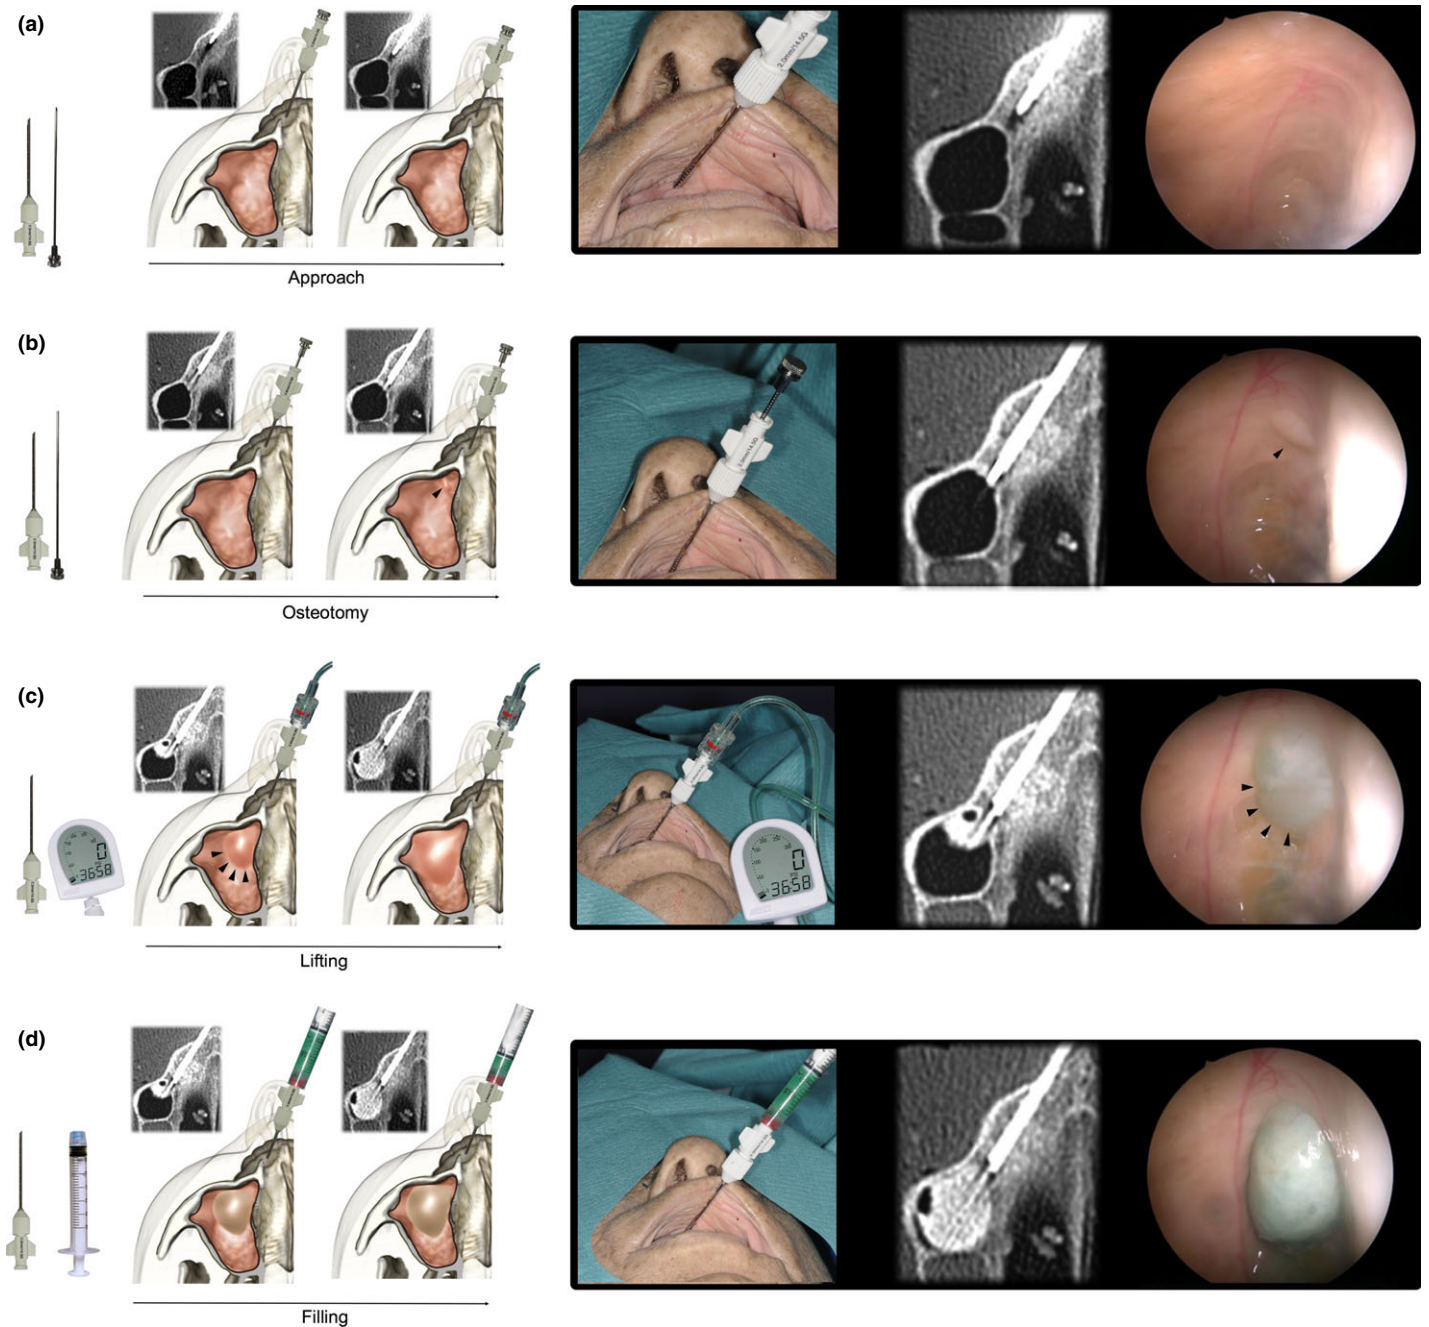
CT-guided radiological maxillary sinus floor elevation stages. The radiological sinus lift technique consists of the following four stages: *approach* through the trabecular bone of the anterior dental sector (a), *osteotomy* to create an osseous window opening into the submucosal space (arrow) (b), *lifting* performed by hydrodissection with a dilute iodinated contrast medium (arrows) (c), *filling* the submucosal space with injection of dilute collagen, visible as a dome shape (d). Note on the endoscopic views the posterior and superior alveolar artery course in the maxillary sinus lateral wall.
